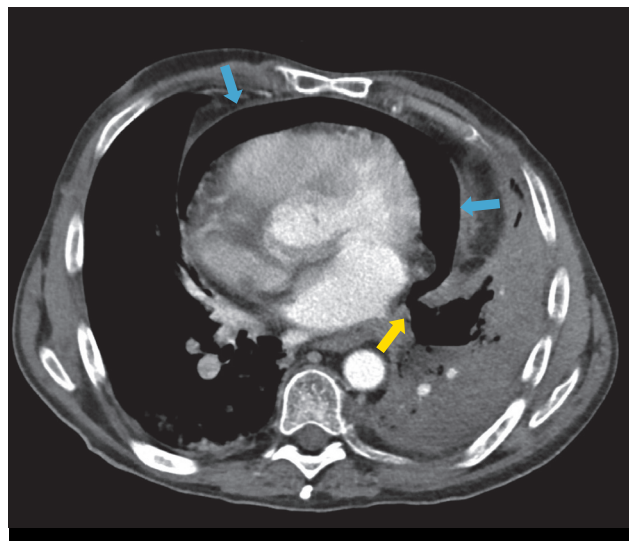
Axial computed tomography image depicting the pneumopericardium (blue arrows), the broncho-pericardial fistula (yellow arrow) and the necrotic lung tumor
